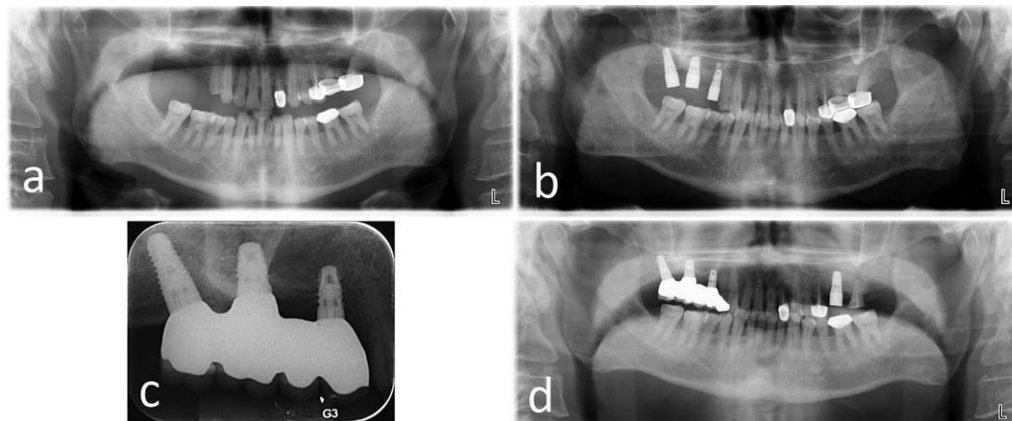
Radiographs after short implant placement. A, Preoperative radiograph; B, Radiograph obtained immediately after short implant placement with osteotome sinus floor elevation. Note the elevation of the sinus membrane; C, Prosthetic load radiograph; D, radiograph obtained at 2 years after short implant placement with osteotome sinus floor elevation. Note the stability of the bone level.
